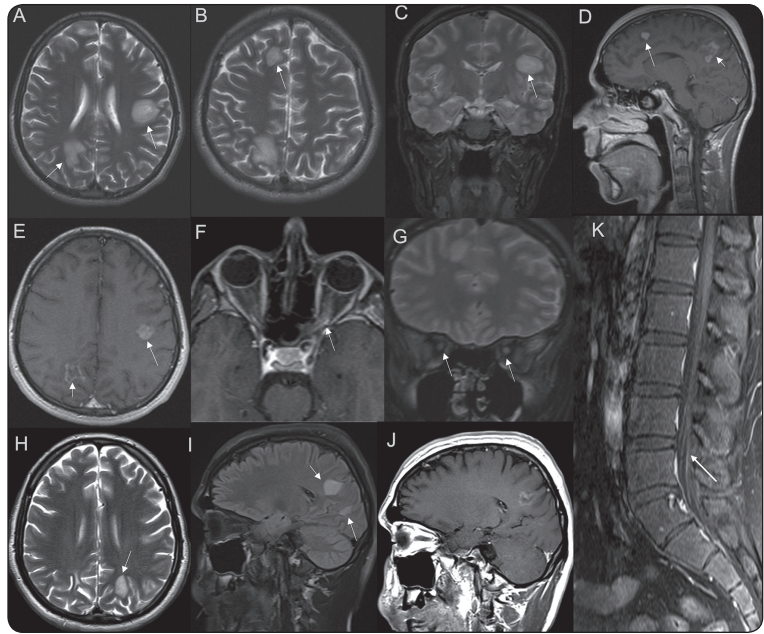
Magnetic resonance imaging (MRI) of the patient in 2003 (A–G) and in 2015 (H–K). Axial (A, B) and coronal (C) T2-weighted images show multiple juxtacortical T2-hyperintense inflammatory-demyelinating lesions (arrows). The sagittal (D) and axial (E) post-contrast T1-weighted images depict open-ring (short arrow) and solid nodular (long arrow) contrast enhancement of the lesions. Orbit MRI (F, G) reveals contrast enhancement (F, arrow) and T2-hyperintensity (G, arrows) of the left optic nerve consistent with optic neuritis. Brain MRI performed during the second attack shows new juxtacortical T2-lesions (H, I; arrows), and contrast enhancement in T1-weighted (J) images. Post-contrast sagittal T1-weighted image reveals cauda equina nerve root contrast enhancement (K, arrow)
